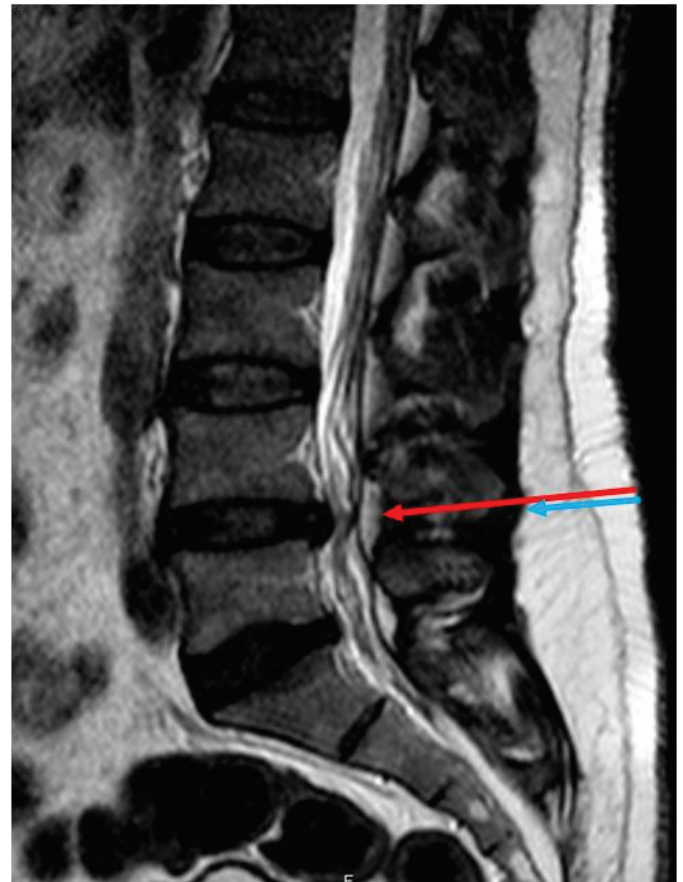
The figure shows the measurement of subcutaneous fat tissue (blue arrow) and distance of the lamina-to-skin (red arrow) on the T1-weighted MRI along the surgical route
